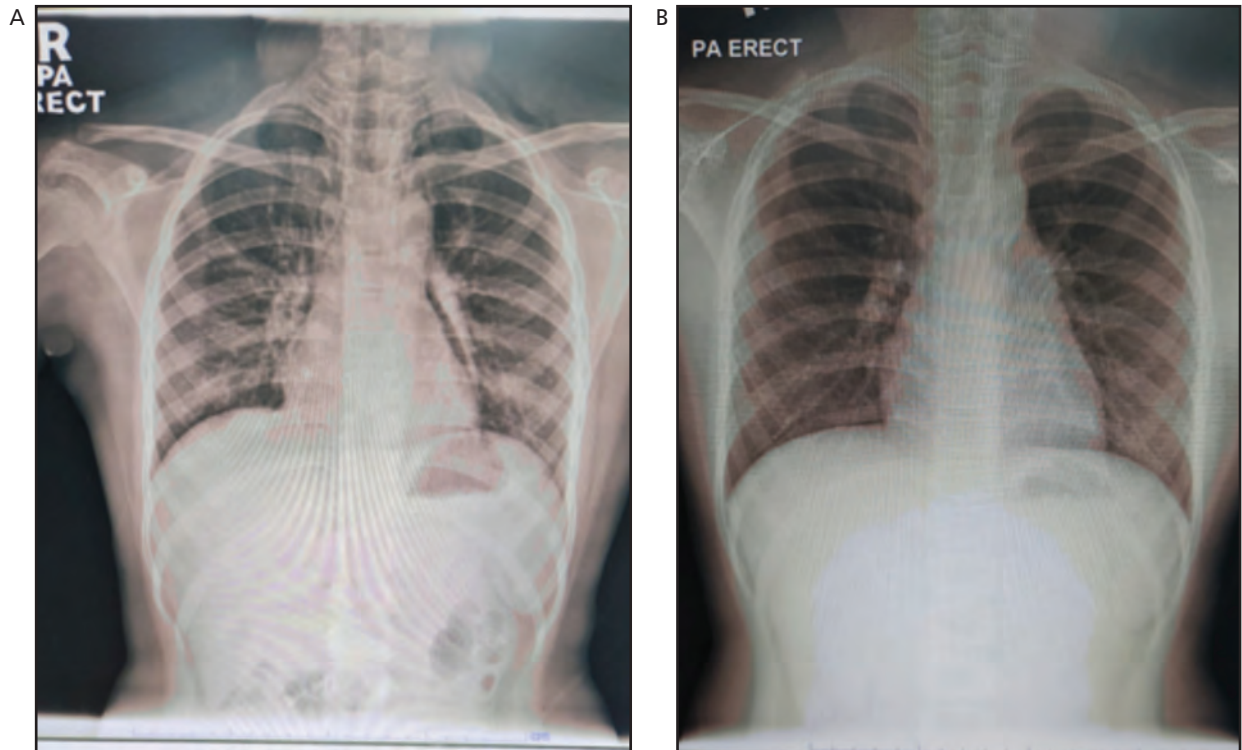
Sequential chest Xray (A) on admission day and (B) discharge day showed improvement of pneumomediastinum and subcutaneous emphysema (red arrow).
